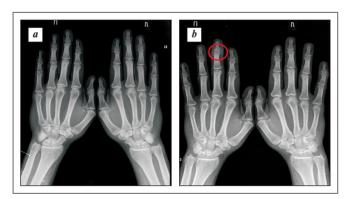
Radiographs of the hands, performed in 2016 (a) and 2019 (b). Increased number of narrowed fissures, erosion of the 3rd distal interphalangeal joint, increased Sharp count
